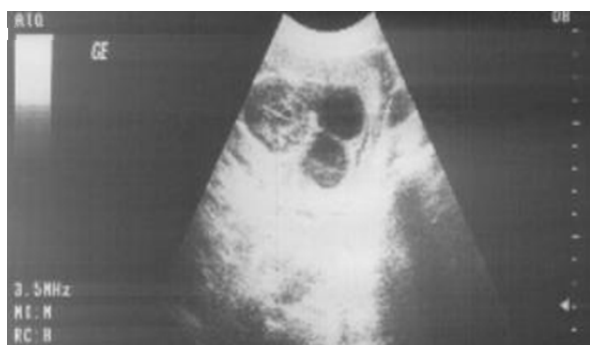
Obstetrical ultrasonography at 10 WP Bi parted off Cystic Hygroma retro cervical.
